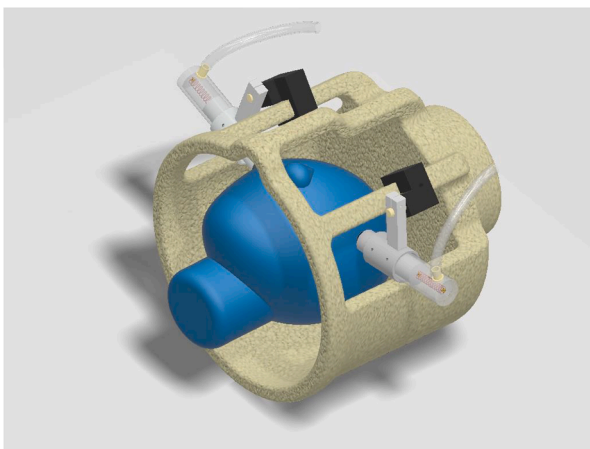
Depiction of the MRE vibration actuator inside the MRI head coil. The two spring-loaded, pneumatically-driven, MRI-compatible pistons are driven out of the phase at 30 Hz to produce a gentle, side-to-side rocking of the head. Net skull motion is < 1 mm.
